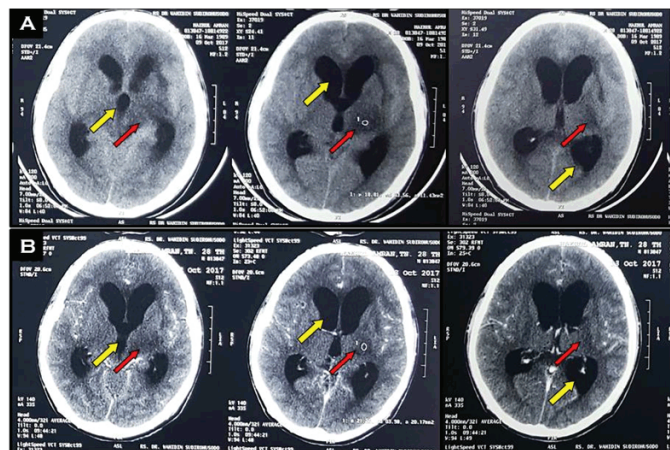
(A and B): Axial section of Head CT Scan without (A) and with (B) contrast, showed hypodense lesion in left thalamus that not enhanced by contrast injection (red arrows), referred to a left thalamus infarction. Yet, both of them showed non-communicating hydrocephalus (yellow arrows).
